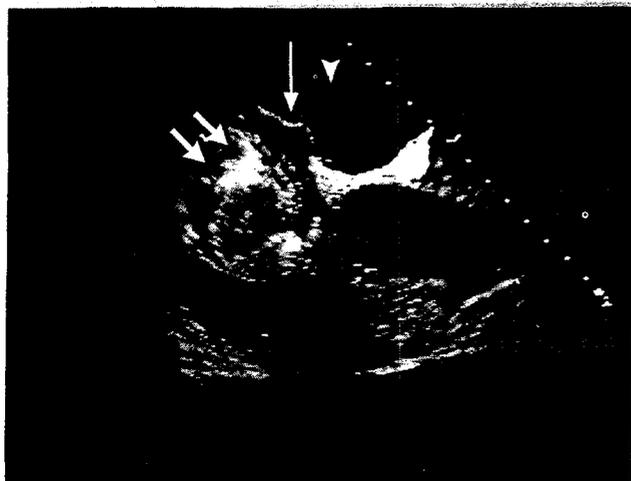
Transesophageal Echocardiogram from a Patient Evaluated for the Presence of a Patent Foramen Ovale.
